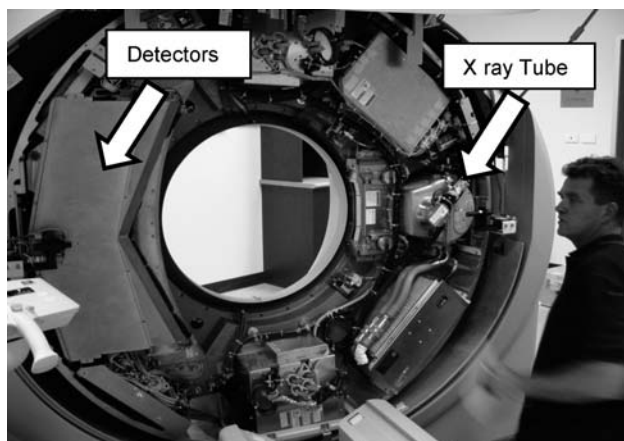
Computed tomography scanner with gantry cover removed. Note the X ray tube on the right hand side with collimator and filters towards the scan aperture. The detectors are on the left hand side.
